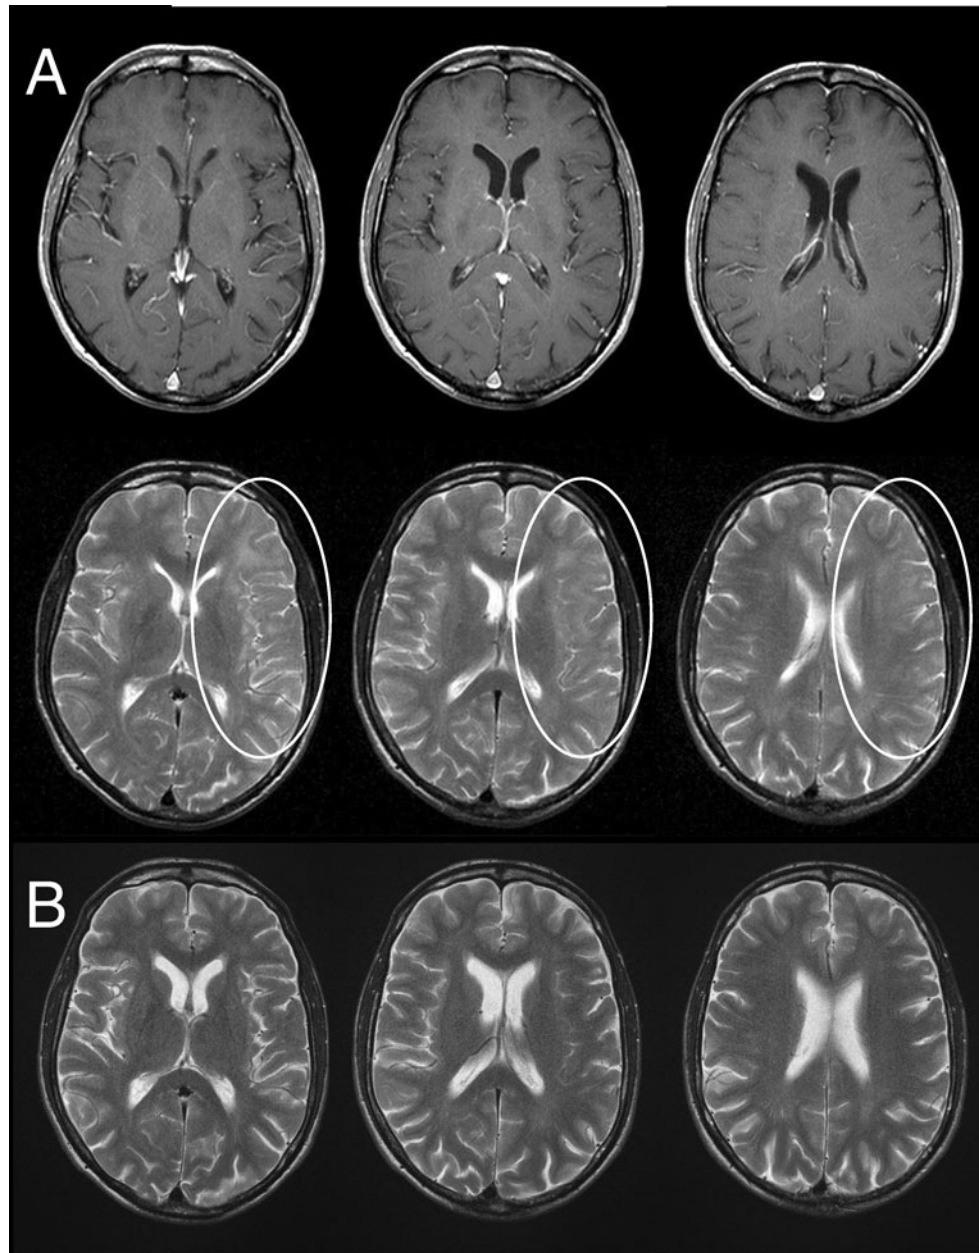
T2-weighted MRI after the second seizure (A) and at 19-month follow-up (B). (A) No contrast-enhancing lesions are detected on T1-weighted images (*upper row*), whereas mainly subcortical T2-hyperintense white matter abnormality is noted most prominently in left frontal areas (*white ellipse; lower row*). Normalization of white matter signal intensity and improved differentiation of grey and white matter is demonstrated on follow-up (B).
